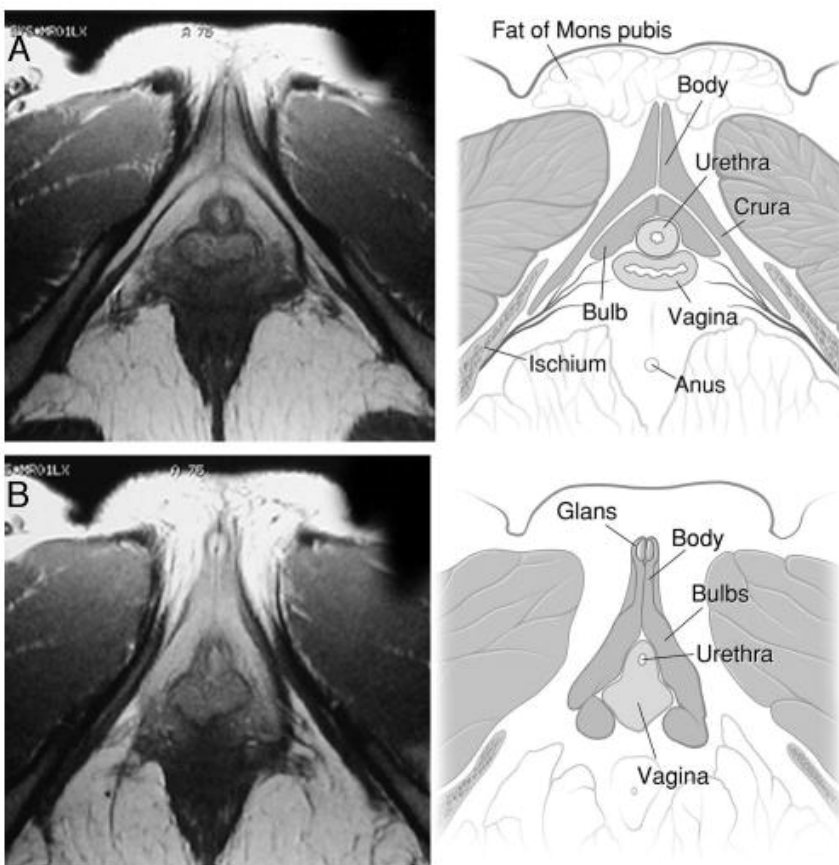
A and B, MRI imaging of the clitoris from O'Connell's 2005 paper depicting the full structure of the clitoris on the axial plane including the internal components; note the bulbs of the clitoris as well as the interconnectedness of the clitoris, urethra, and vagina
